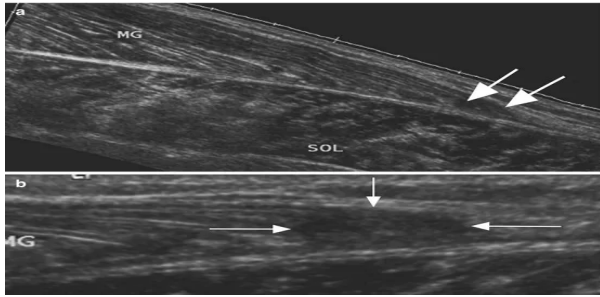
Longitudinal ultrasound image shows grade 1 muscle strain with mild hypoechoic interstitial edema and preserved fibrillar pattern.
